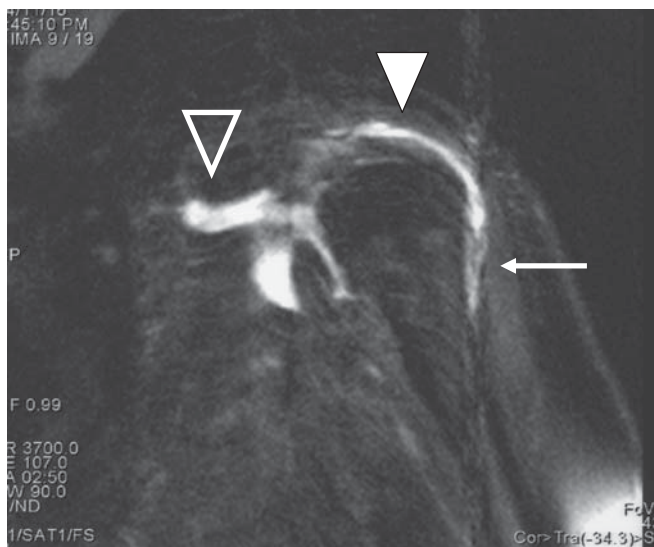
Fat suppression MRI findings of the left shoulder from a PMR patient without peripheral arthritis. The coronal image of FS-T2W shows subacromial (*white arrowhead*), subdeltoid (*white arrow*) bursitis, and glenohumeral joint synovitis (*open arrowhead*). No abnormalities are visible in extracapsular sites around the shoulder joint
